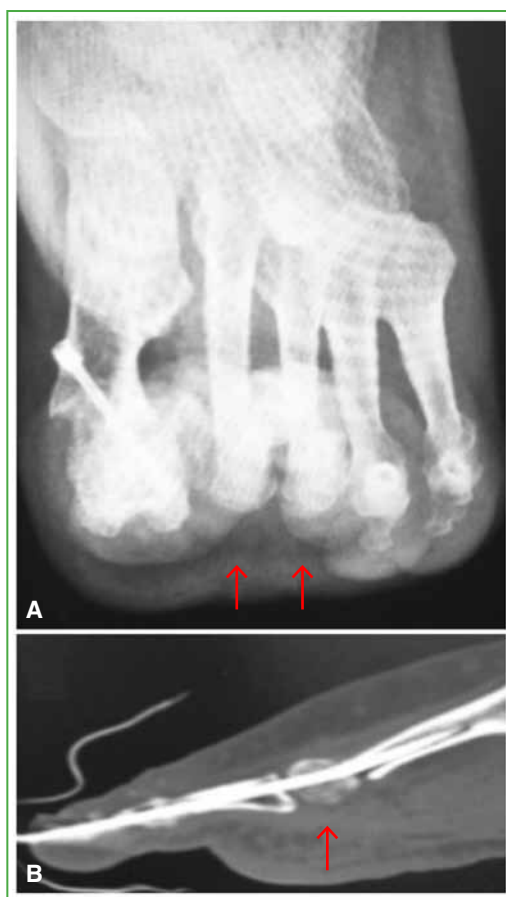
Elevation of the metatarsal heads. A. Sesamoid radiograph, axial view. B. Computed tomography of the forefoot, sagittal section. The red arrows indicate the elevation of the metatarsal heads.
